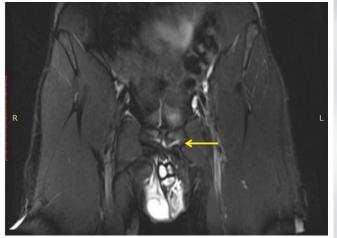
Magnetic resonance imaging in coronal STIR view shows a hyperintensity signal zone (arrow) starting from the middle of the pre-pubic aponeurotic complex and propagating unilaterally on the left side.
